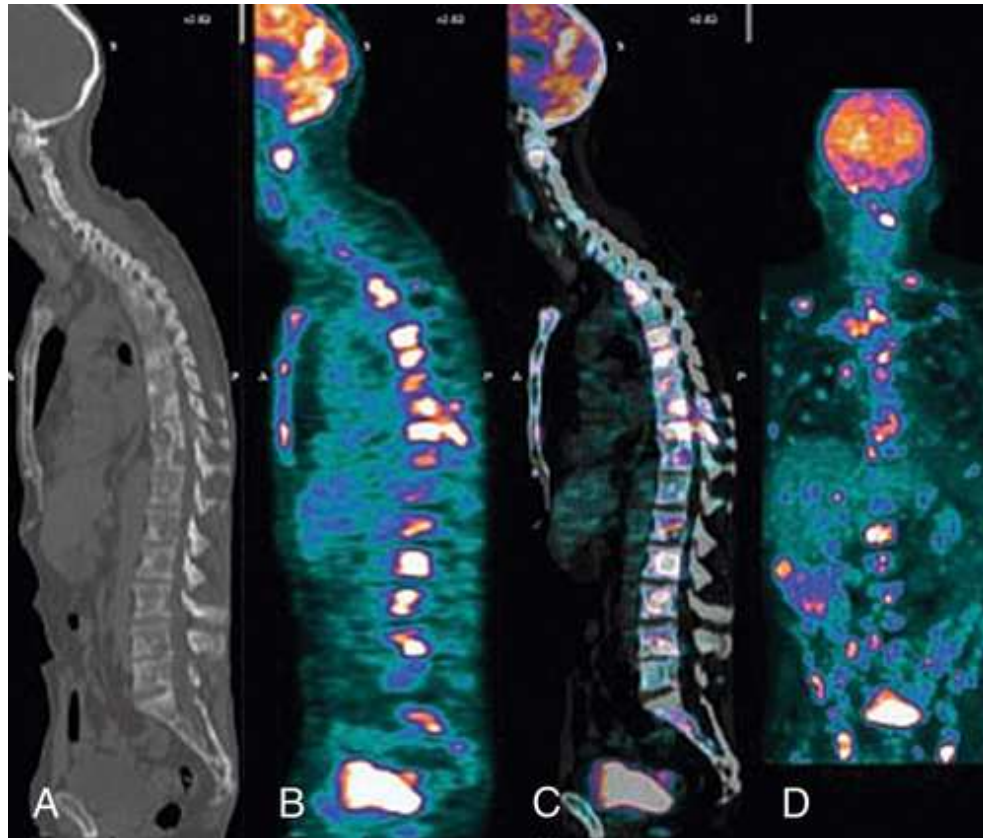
Sagittal reformatted CT scan (A), sagittal PET (B), PET/CT fusion image (C), and coronal PET (D).
